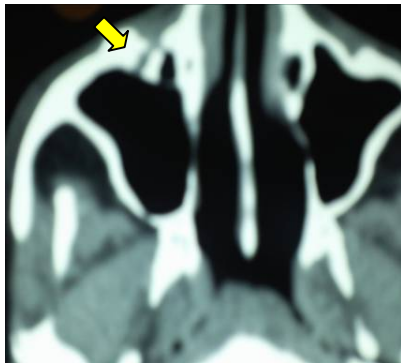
Photograph showing CT of another case with fractured inferior orbital rim impinging on the infraorbital foramen. (Case No.2)
